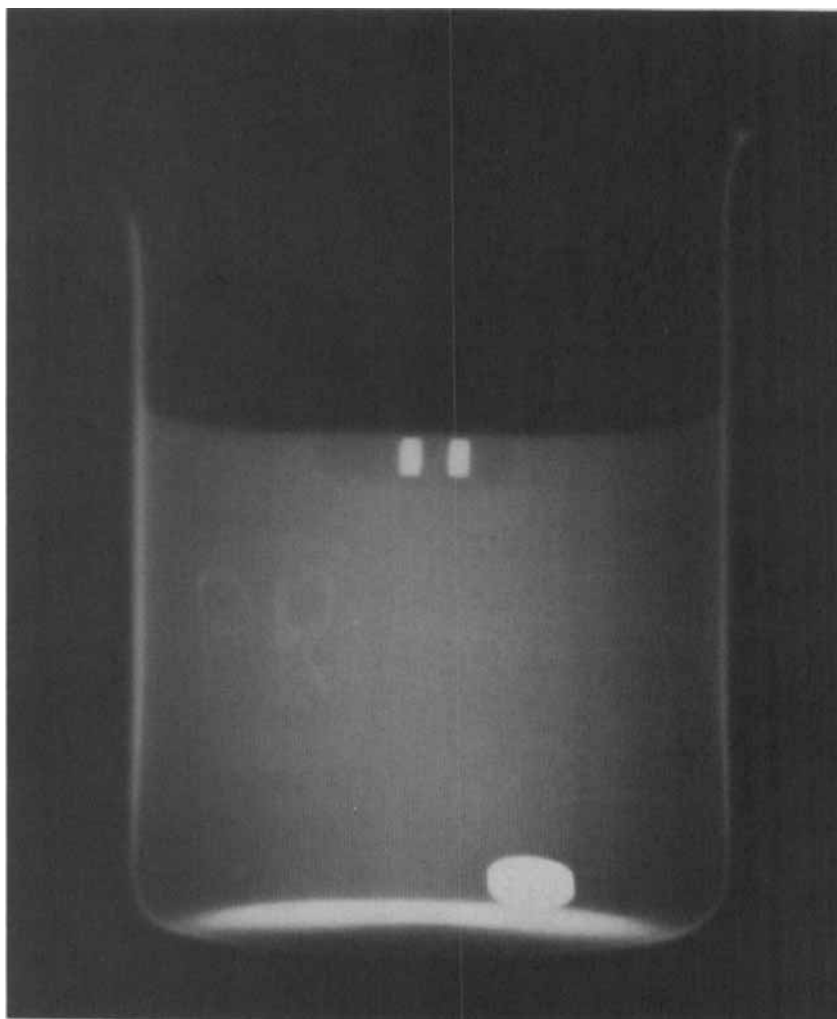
X-ray of HBS and conventional capsules with radiopaque BaSO_4 tablets. The HBS has two BaSO_4 tablets within it to facilitate identification.
